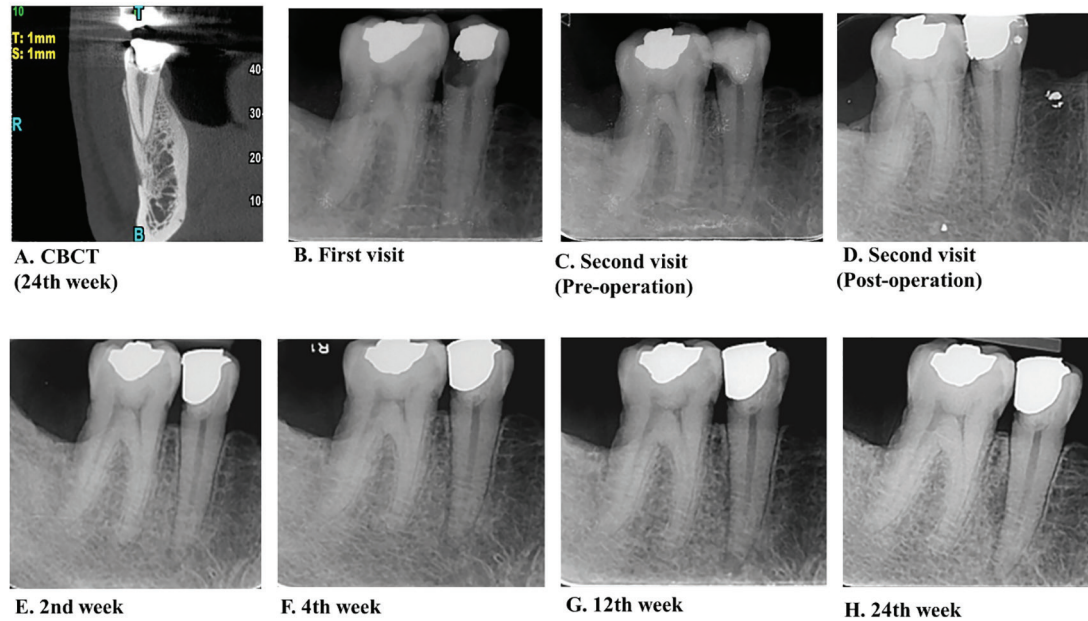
Mandibular second premolar was imaged with cone beam computed tomography (CBCT) and periapical radiographs. The CBCT imaging shows the target tooth at the 24th week after transplantation of chitosan and human umbilical cord mesenchymal stromal/stem cells (hUCMSCs)-derived exosomes in pulpectomized teeth (A). The periapical imaging analysis shows the changes and evolution of periapical tissues at the first visit (B), pre-operation just before chitosan and hUCMSCs-derived exosomes transplantation (C), post-operation just after chitosan and hUCMSCs-derived exosomes transplantation and completing tooth restoration (D), and 2 weeks (E), 4 weeks (F), 12 weeks (G), and 24 weeks (H) following the transplantation of chitosan and hUCMSCs-derived exosomes in pulpectomized teeth.
